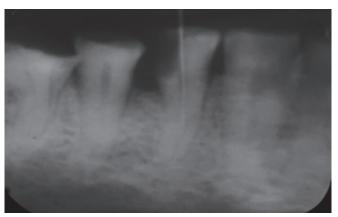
Intraoral periapical radiograph of irt 34 (Case 1)
